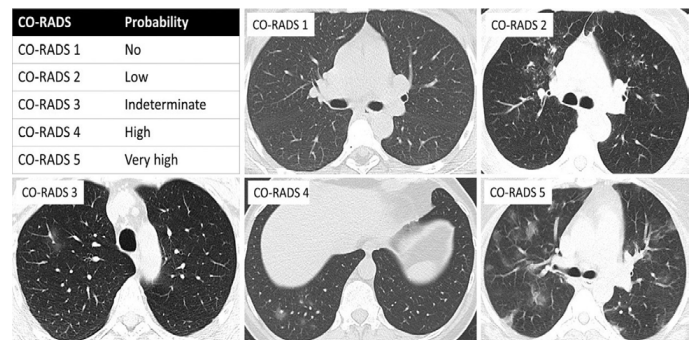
Axial CT plain images showing CORADS grading.
